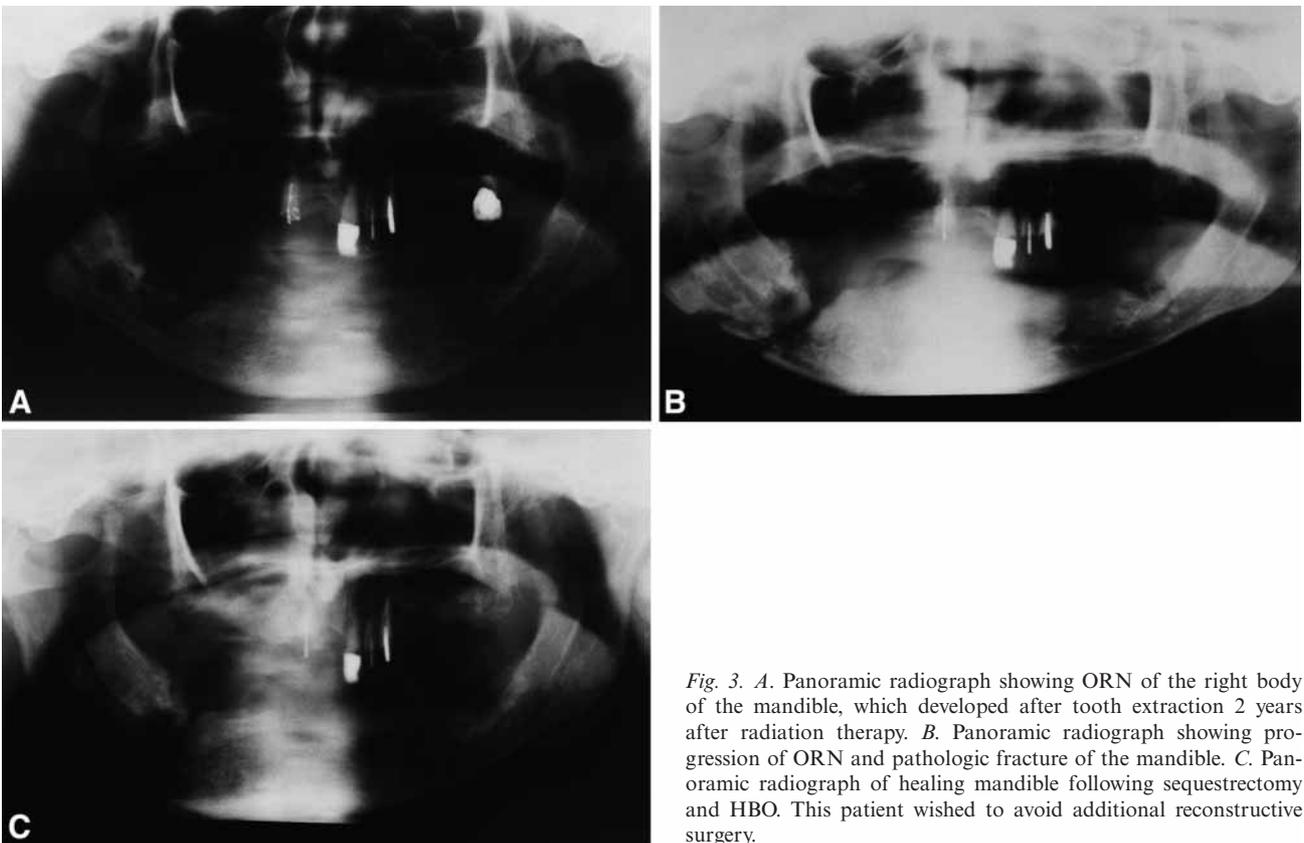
A.* Panoramic radiograph showing ORN of the right body of the mandible, which developed after tooth extraction 2 years after radiation therapy. *B.* Panoramic radiograph showing progression of ORN and pathologic fracture of the mandible. *C.* Panoramic radiograph of healing mandible following sequestrectomy and HBO. This patient wished to avoid additional reconstructive surgery.
